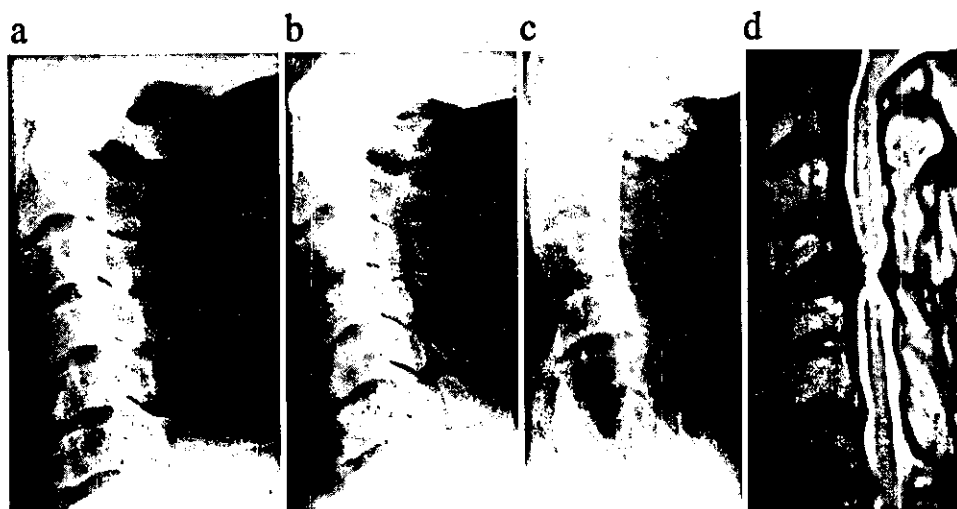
Representative radiographs (a-c) and magnetic resonance image (d) obtained in a 55-year-old man who suffered late-onset deterioration caused by the progression of ossification. In this case, the cervical spine ankylosed at the C2-4 and C5-7 regions separately after surgery, and a 10-mm posterior progression of the ossified ligament was observed at the mobile C4-5 segment. Preoperative upper-extremity JOA and trunk score was 3, which improved to 8 at 1 year; however, it decreased to 5 at 10 years. The images were obtained before (a), 1 year after (b), and 10 years after (c and d) open-door laminoplasty.
